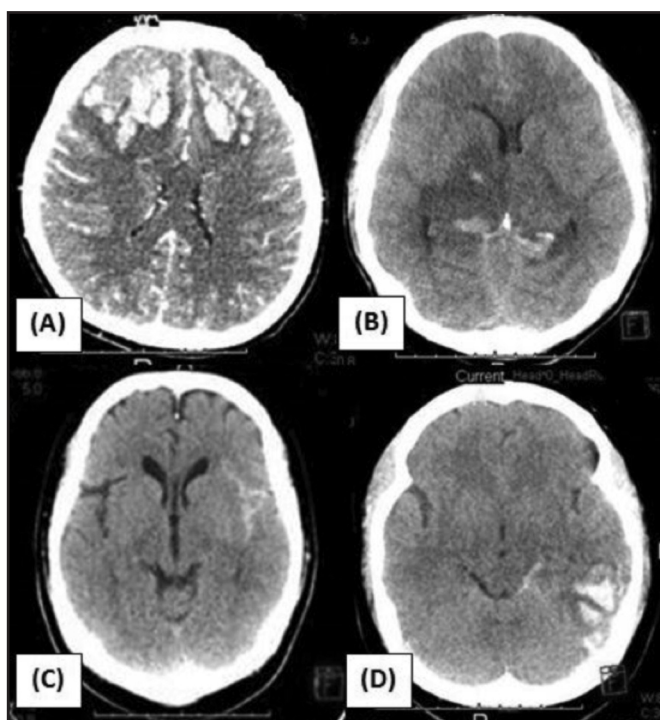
The various radiological findings seen on the initial CT scan done during admission. (A) bifrontal haemorrhagic infarct; (B) deep nuclei infarct with haemorrhagic transformation; (C) left sylvian fissure subarachnoid haemorrhage; (D) left parieto-occipital haemorrhage.
